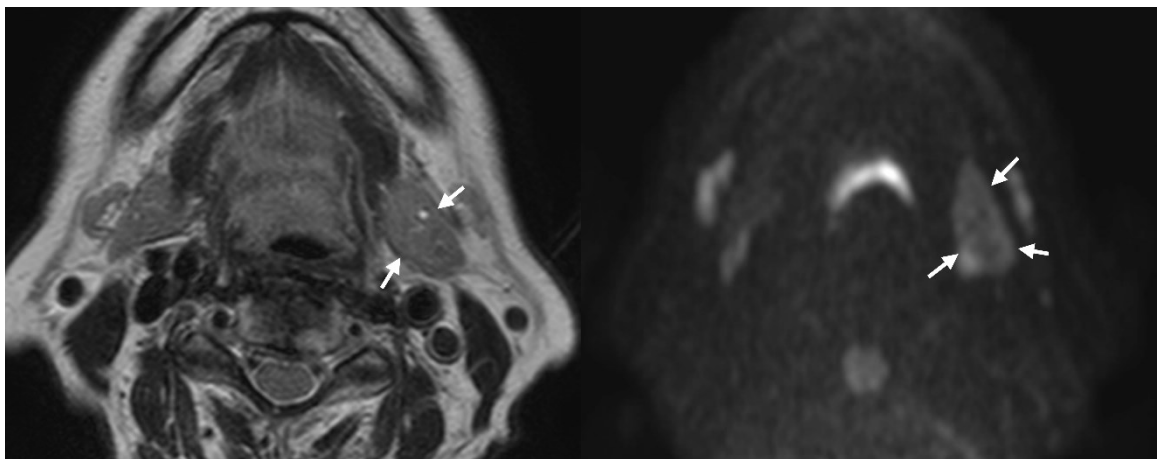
72-year-old female with submandibular sialadenitis. T2-weighted image (A) shows no internal abnormal signal intensity in the slightly swollen left submandibular gland
